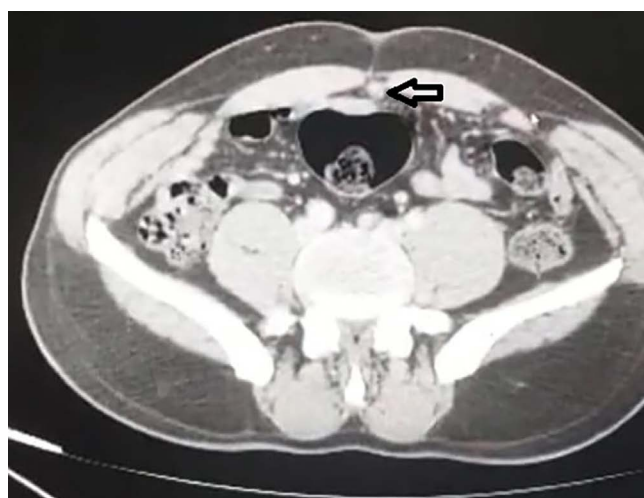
Computed tomography of the urachal sinus (black arrow)
